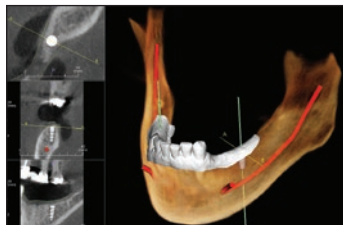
The CBCT reconstruction with an optical impression of a patient superimposed over the virtual rendering of the patient's jawbone structure (Invivo [Anatomage]).
